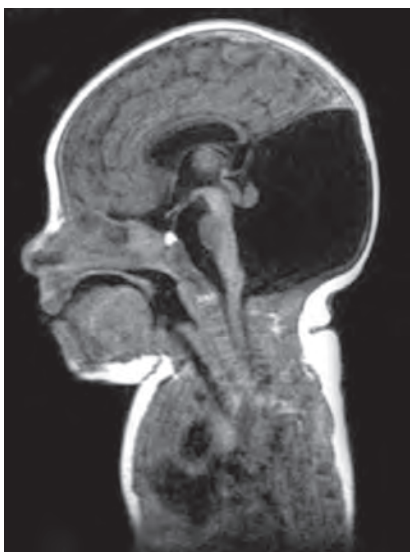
MRI of the brain T1W sagittal image showing Dandy Walker malformation
